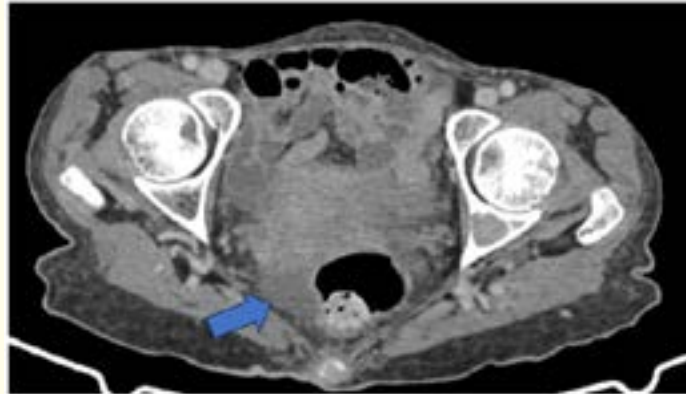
Axial portal venous-phase pelvic CT scan demonstrating a minimal amount of peritoneal fluid (minimal ascites) within the pelvic cavity (Blue arrow).
